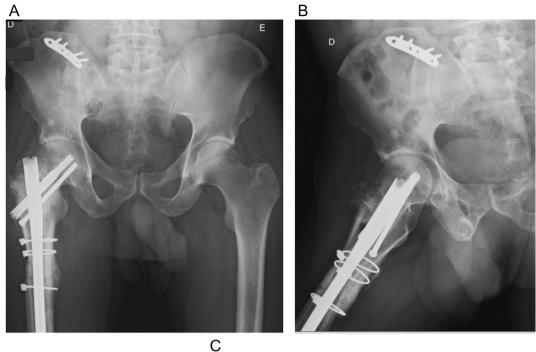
A, B and C - 12-month post-operative pelvis and right hip radiographs, which show uneventful union of the fractures.
